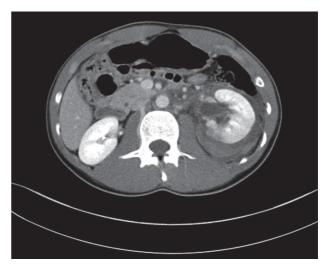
Follow-up CT showing dilated pelvis filled with hematoma.
